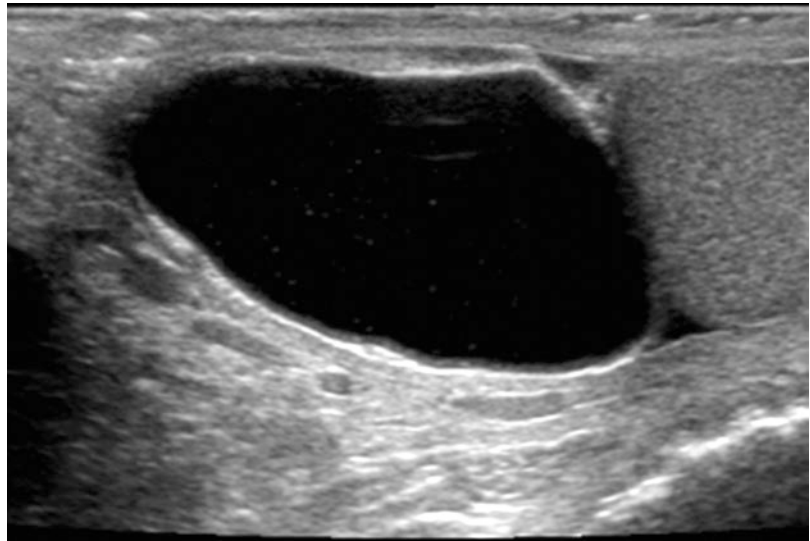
Cystic epididymal mass: longitudinal sonogram shows a large cystic mass of the epididymal head, along the superior aspect of the testis. Spermatocele is likely a diagnosis, particularly given the few low-level echoes within the mass
